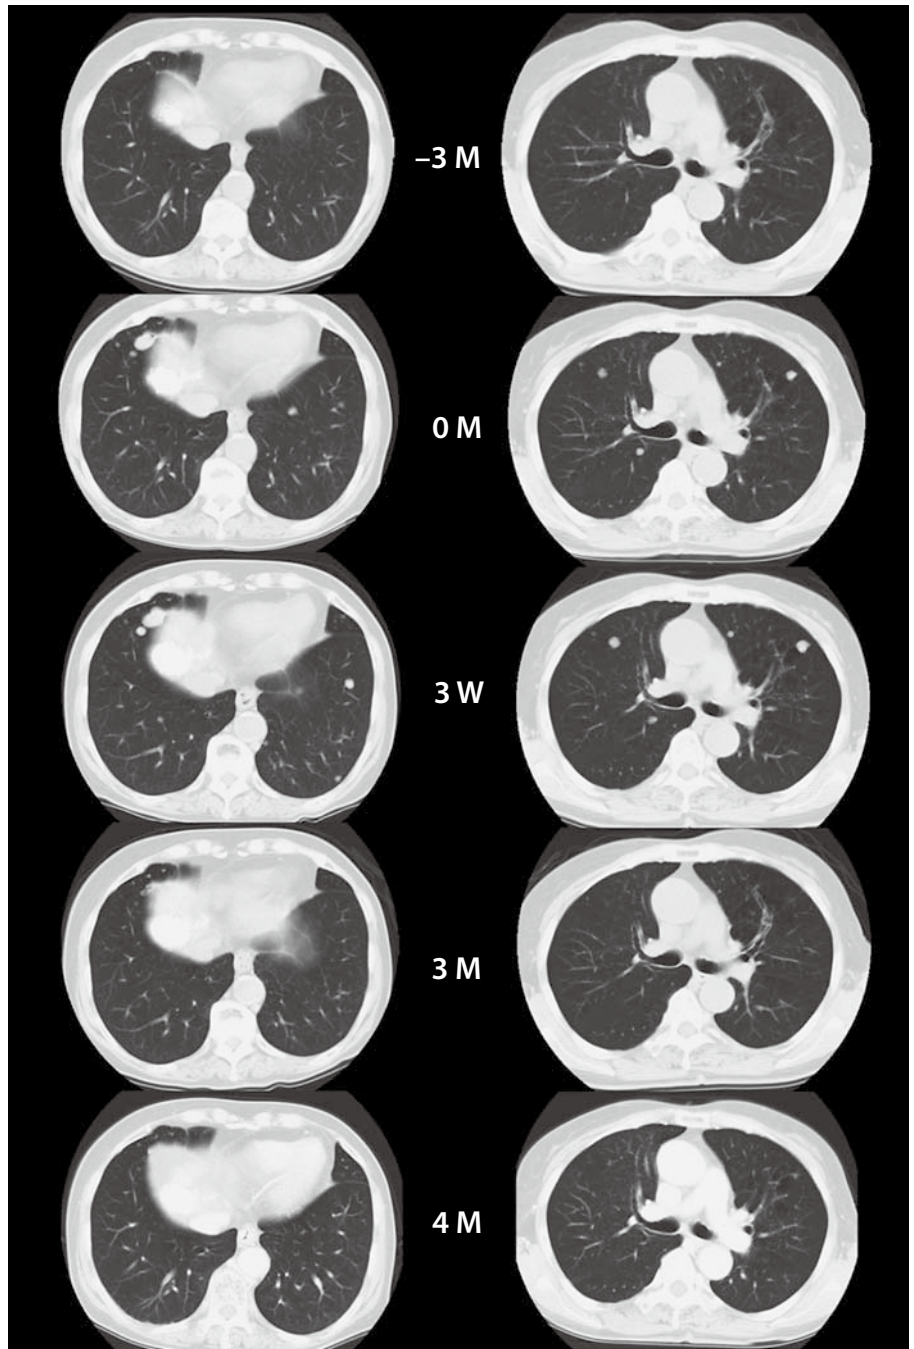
Changes in chest CT scans. Follow-up CT scans show that multiple lung metastases were slightly enlarged after 3 weeks. After 3 months, they had almost disappeared. After 4 months, they had completely disappeared and the patient achieved radiological CR. The maximum diameter of lung metastases 3 weeks after commencement of therapy was 2 cm.
